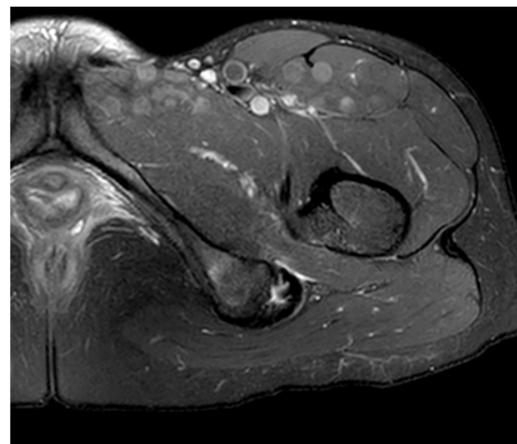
Proximal hamstring syndrome axial view MRI.
